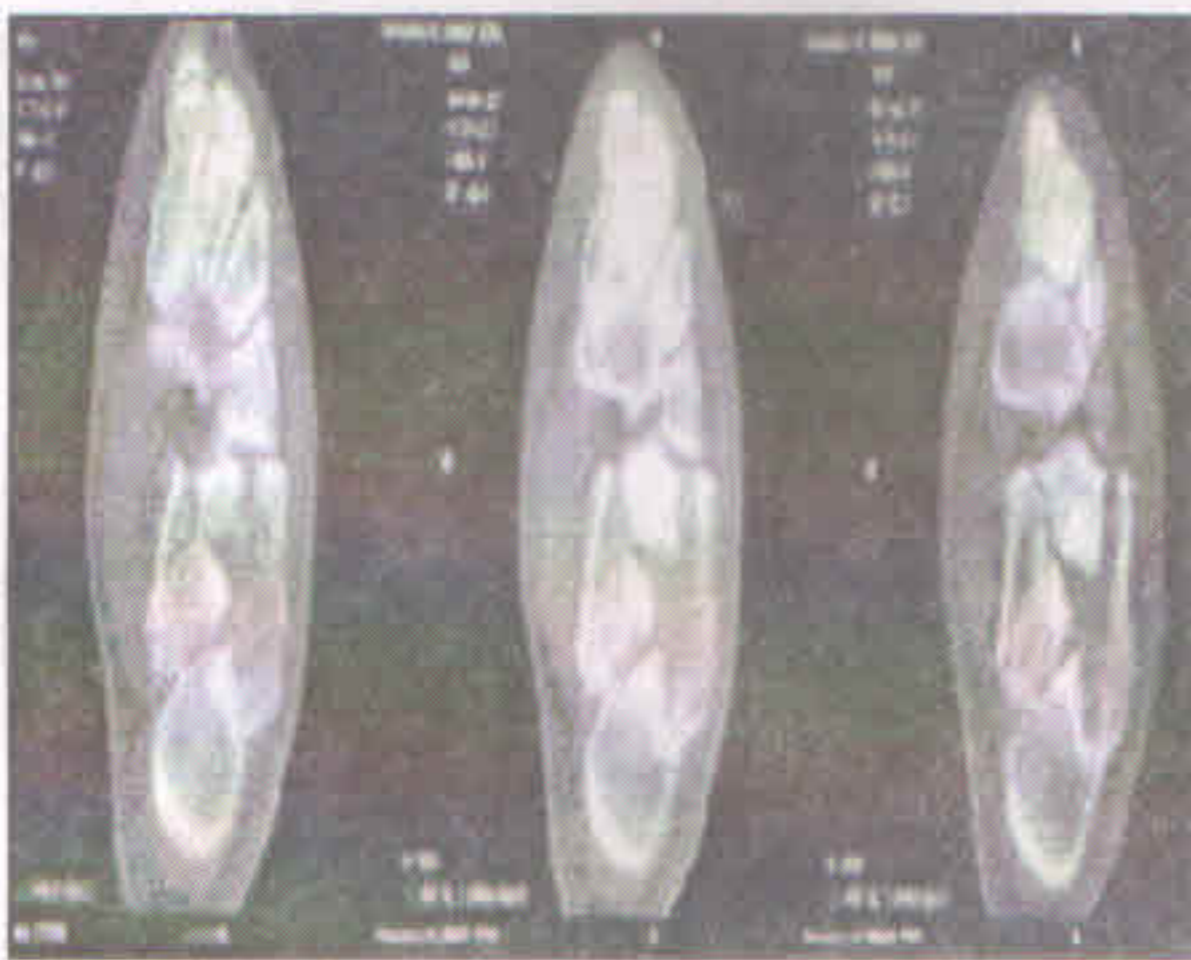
Pre-operative CT Scan
